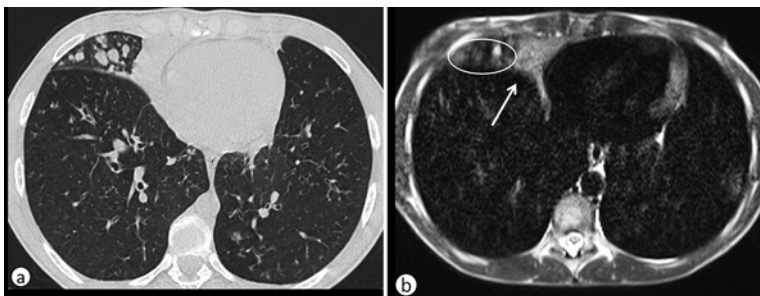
a and b SSFSE/HASTE in CF. CF patient, CT image (a) and SSFSE (b) at end-inspiration. Note the consolidation in the right middle lobe (white arrow) and the adjacent bronchi filled of mucus (white circle).
